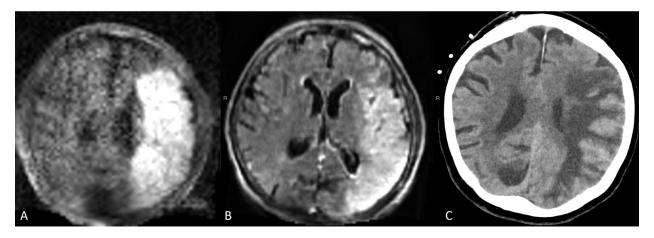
79 year old female who presented to hospital with cerebellar infarct and obstructive hydrocephalus, with fluctuating level of consciousness in the ICU. pMRI showed new left MCA territory infarct on DWI (A) and FLAIR (B), confirmed on subsequent CT head (C) performed 3 days later.
